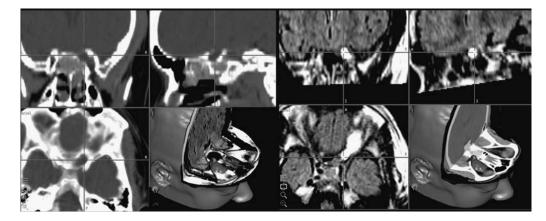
A CT/MRI FLAIR fusion in the patient whose images are shown in Figure 32.3 ("ImMerge" StealthStation).
